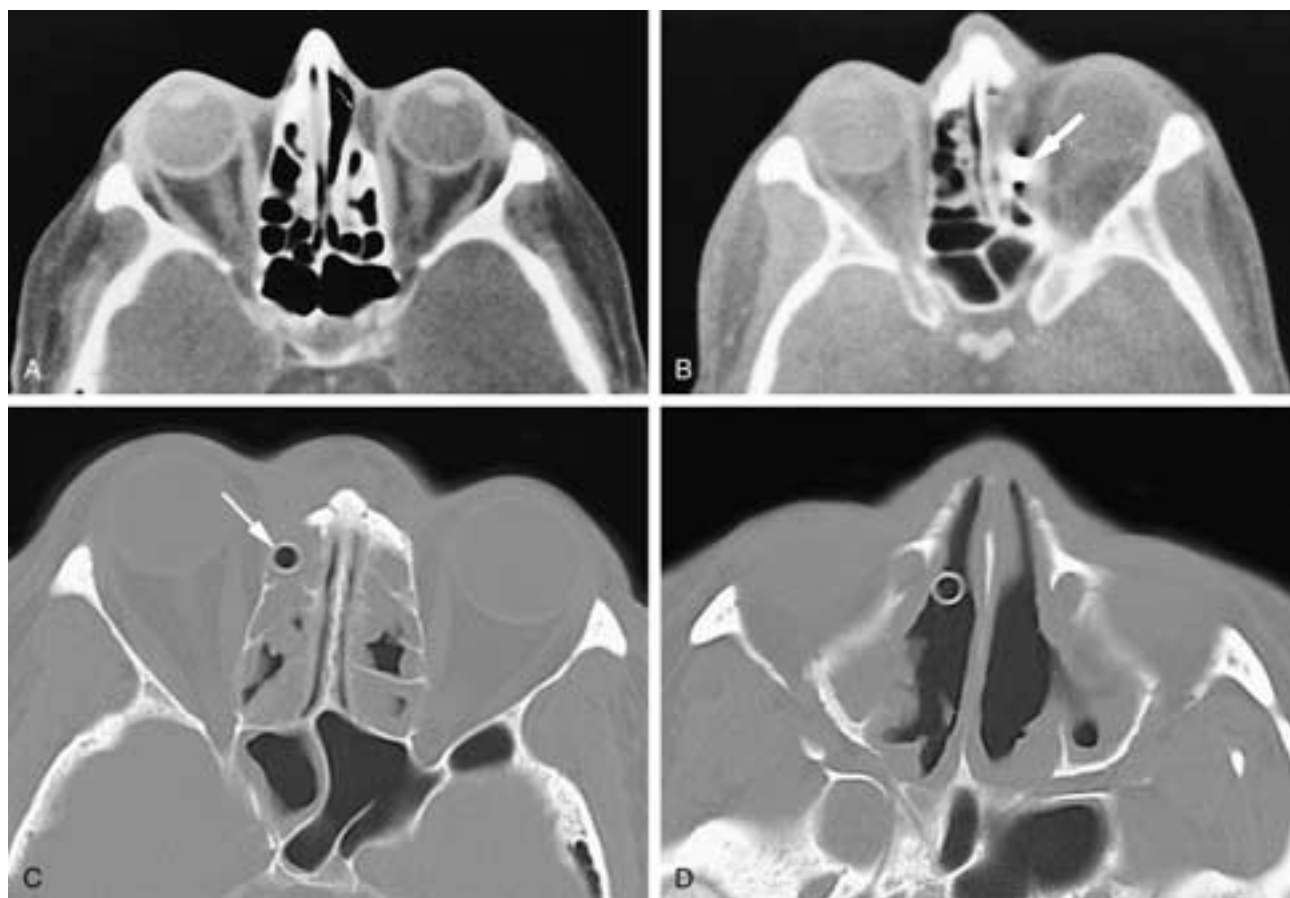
Axial CT scan (A) shows the postoperative appearance of a left external ethmoidectomy. The anterior lamina papyracea has been surgically removed and is replaced by fibrosis (*arrow*). Axial CT scan (B) shows a patient's status after a left external ethmoidectomy. The surgical clip (*arrow*) is used to control bleeding from the ethmoidal vessels. The soft tissue in the anterior ethmoid cavity was fibrosis and granulation tissue in this asymptomatic patient. Axial CT scans (C, D) on another patient show that a Lynch procedure was performed on the right side, and the drainage tube extends from the frontal sinus down through the ethmoid (*arrow* in C) sinus into the right nasal fossa (D).
